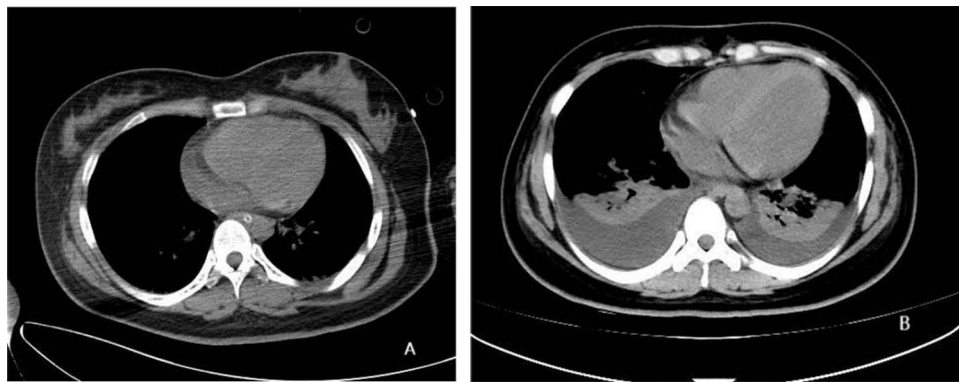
(A) Chest CT (mediastinal window) on hospital day 2 reveals a small amount of bilateral pleural effusion. (B) On day 18, bilateral pleural effusion has increased, accompanied by interstitial pulmonary edema in both lungs.
